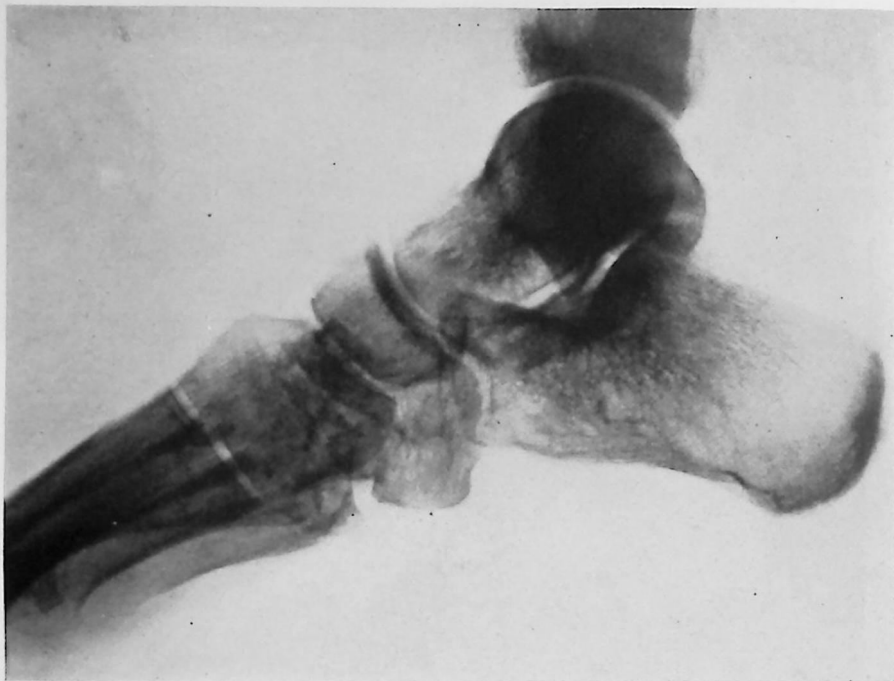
Radiograph five months after injury shows complete regeneration of the destroyed bones, in particular the cuboid. No signs of osteitis.
